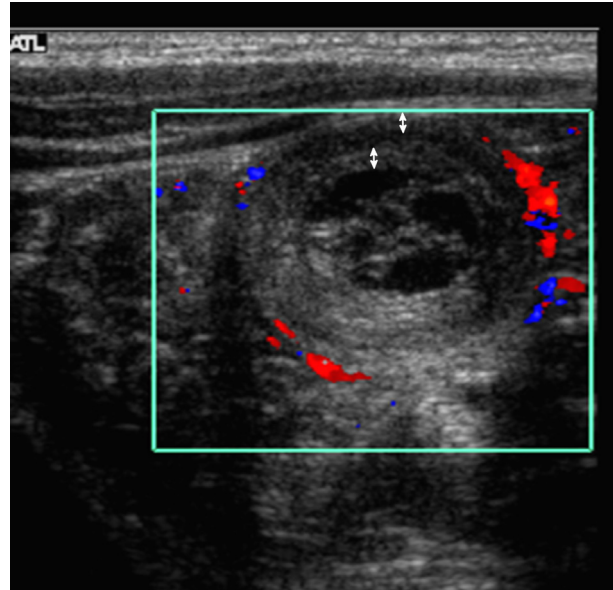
Abdominal Doppler ultrasound, transverse view. There is fluid and echogenic material trapped inside the intussusception. Arrows indicate the concentric layers of the bowel walls.
